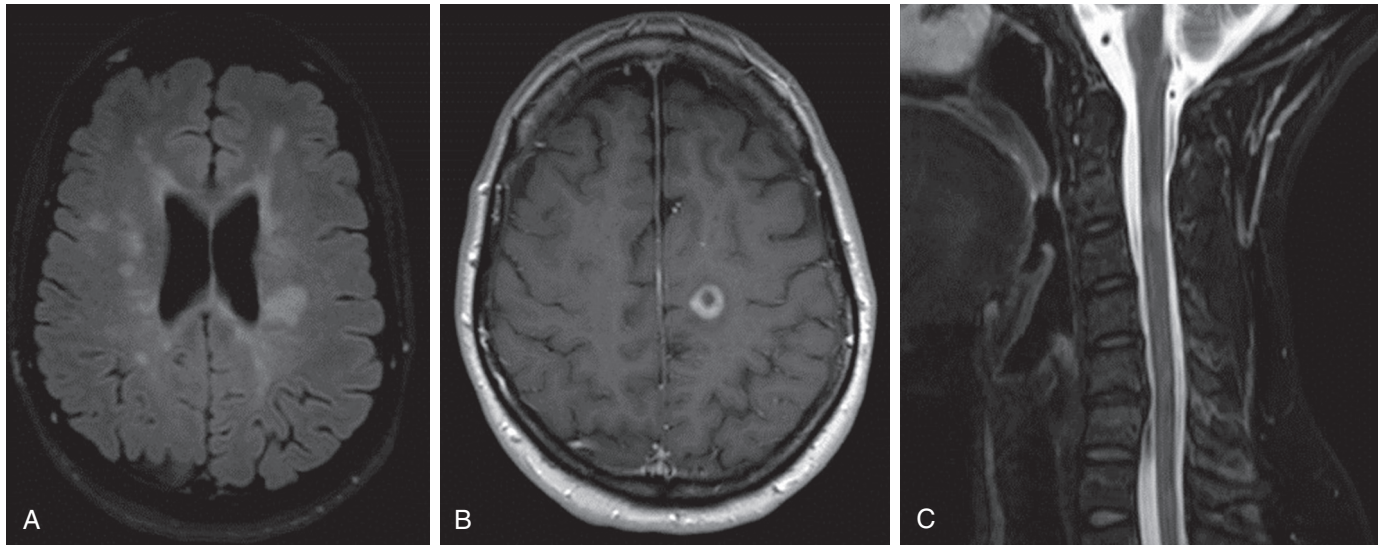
Magnetic resonance imaging (MRI) of the brain and cervical spine of a patient with multiple sclerosis (MS). A, Axial T2 MRI brain with large areas of increased signal intensity adjacent to the lateral ventricles in the classic distribution typical for MS. B, Axial T1 MRI brain after gadolinium contrast agent with a ring-enhancing lesion in left centrum semiovale. C, Multiple cervical spine lesions, T2 sequence with increased signal intensity at multiple levels.
